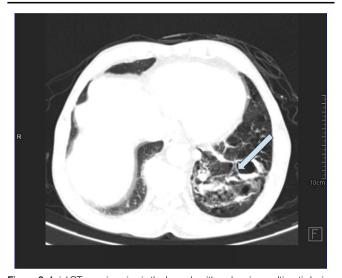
Axial CT scan imaging in the lung algorithm showing multicystic lesion in the left lower lung lobe with a few intralesional cysts showing an air-fluid level and supplied by an aberrant artery arising from the descending thoracic aortapulmonary sequestration (infected) with cystic degeneration. COPD (chronic obstructive pulmonary disease) changes with centrilobular emphysema and cardiomegaly were noted in bilateral lung fields.
